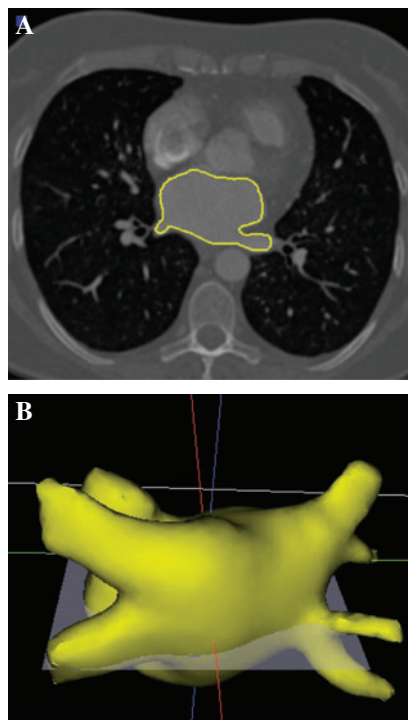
Patient 1 – automatic segmentation of LA. (A) Transversal slice of the angiographic CT data set. The automatically segmented LA is displayed by a yellow line. (B) Three dimensional model of the segmented LA. The picture on the left was taken from the indicated layer.
